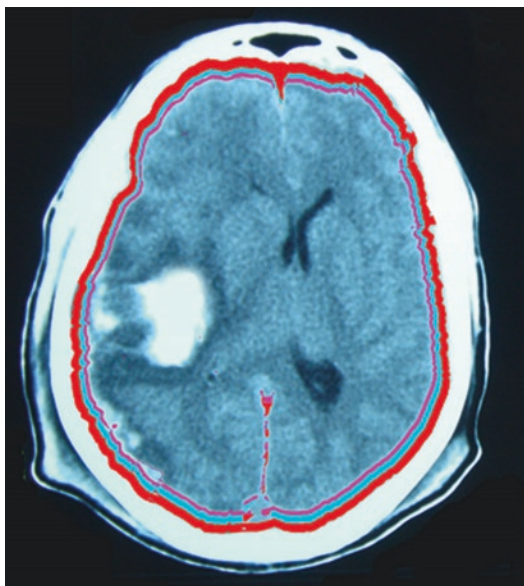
CT scan showing traumatic intracerebral hematoma—within the parenchyma of the brain—for instance inside the pia mater
